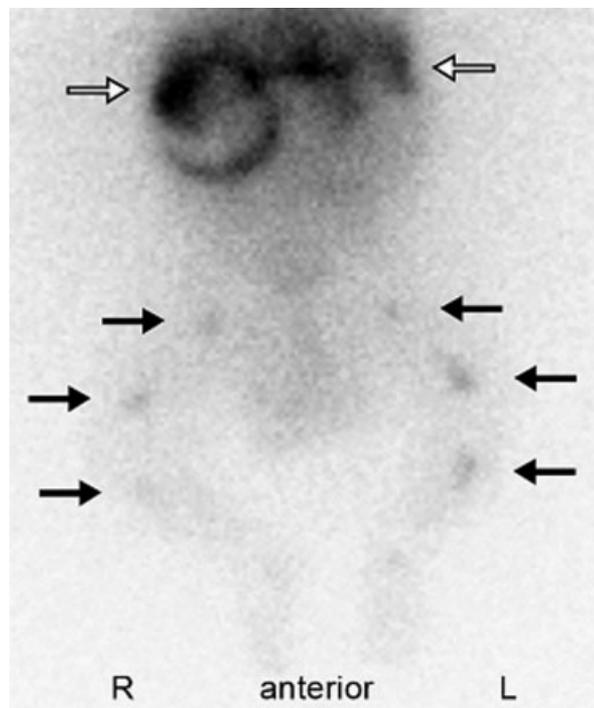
^{123}I -MIBG 40 MBq scintigraphy in the patient at 2 months of age with tracer accumulation in projection of the adrenal glands (white arrows) and the bone marrow (black arrows) of both femora and tibiae (anterior view; R stands for right and L for left side).
